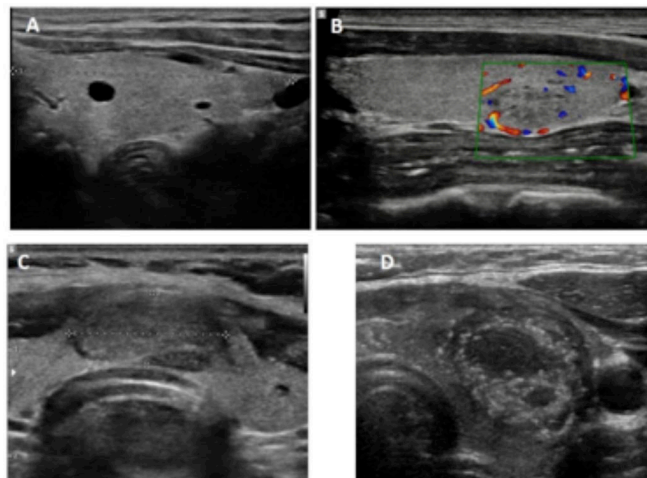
Ultrasound features of thyroid nodules
